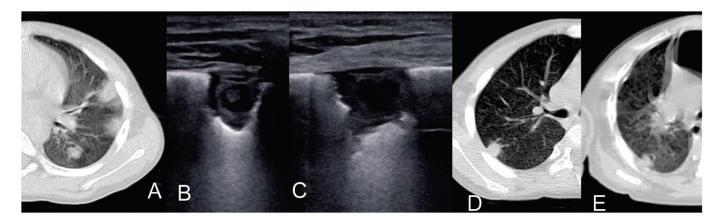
Comparison between LUS images and CT images in fungal pneumonia [40].
